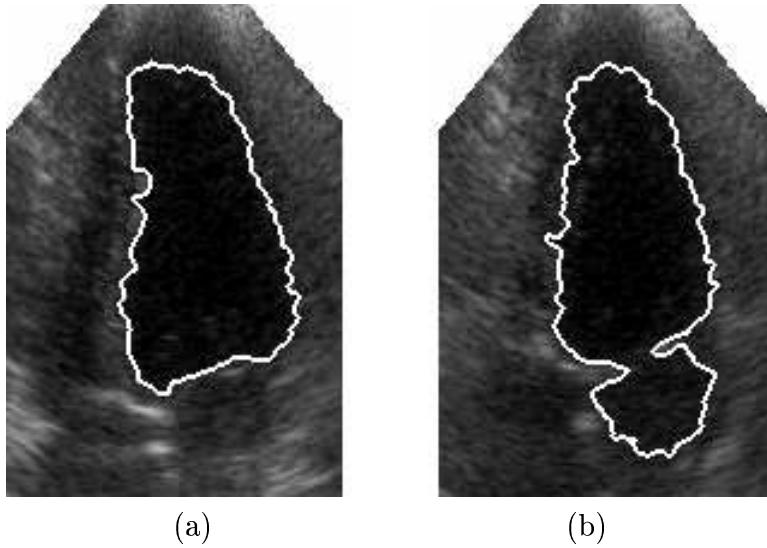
(a) and (b) are two echocardiographic images with the boundaries obtained by the proposed approach.
